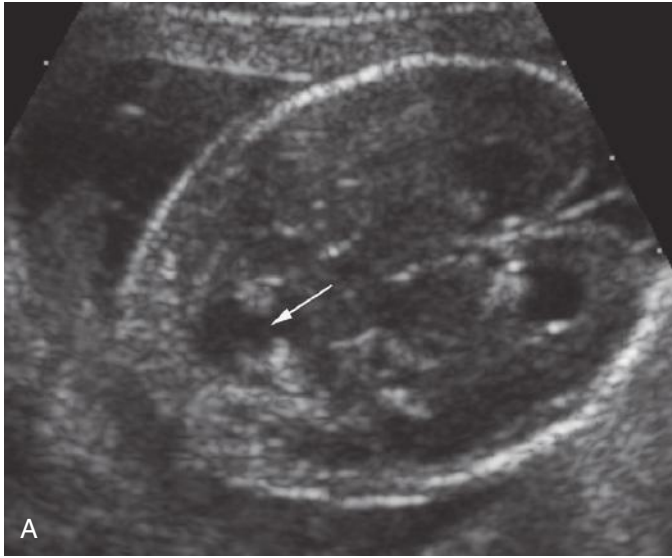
A, Sonogram of a fetus at 17 weeks' gestational age. In the posterior fossa, fluid is seen in the midline (*arrow*) and the cerebellar vermis appears to be absent. B, A scan of the same patient at 25 weeks reveals a normal vermis (*arrow*), which does not fully form until the middle of the second trimester.
